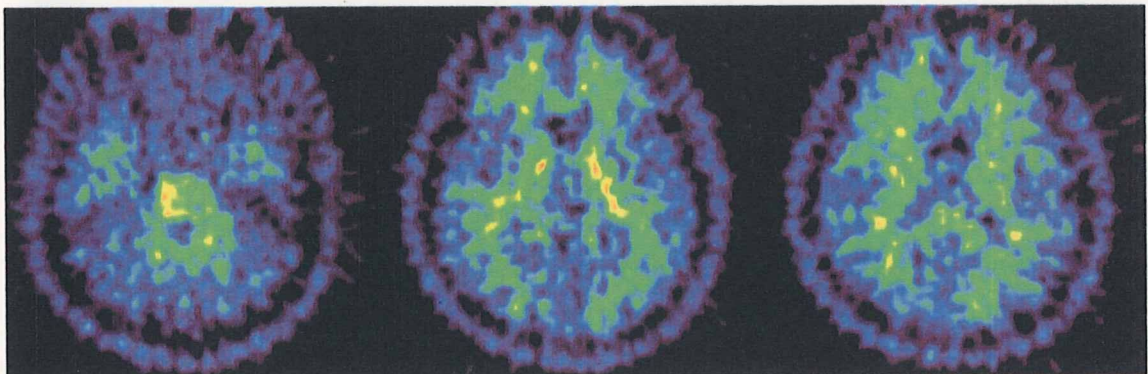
アルツハイマー病患者におけるPiB後期SUVR画像の平均イメージ 健常者と同様で、50-70分の加算画像を小脳皮質への集積で基準化したもので、20例分を平均した画像を示す。大脳白質のレベルを超える集積が連合野皮質の広範な領域で認められる。楔前部・後部帯状回領域への集積が最も高く、次いで前頭葉、側頭頭頂葉外側皮質が高い。また線条体（特に腹側部）にも大脳白質レベルを超えた集積が認められる。後頭葉一次視覚野、中心前後回への集積は相対的に目立たない（しかし、健常者よりは高い）。側頭葉内側部（海馬、扁桃核）や島皮質への集積も比較的目立たない。脳室周囲の白質への集積、橋への集積、小脳皮質への集積は健常者と比べて有意な変化はないといわれているので、読影の際に目安とすることが出来る。
